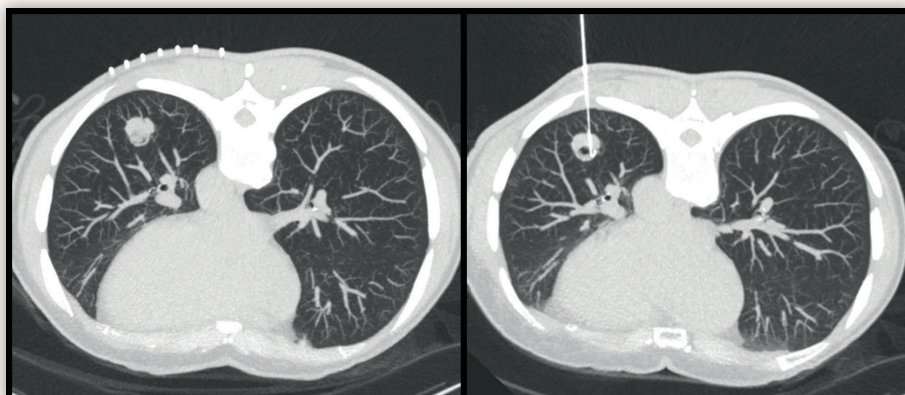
(left) Different stages of CT-guided percutaneous hookwire localization. For demonstration purposes an example of one of the largest nodules was chosen. Optimal puncture site is chosen. Figure 3. (right) Different stages of CT-guided percutaneous hookwire localization. For demonstration purposes an example of one of the largest nodules was chosen. The hookwire system is inserted into the nodule.
